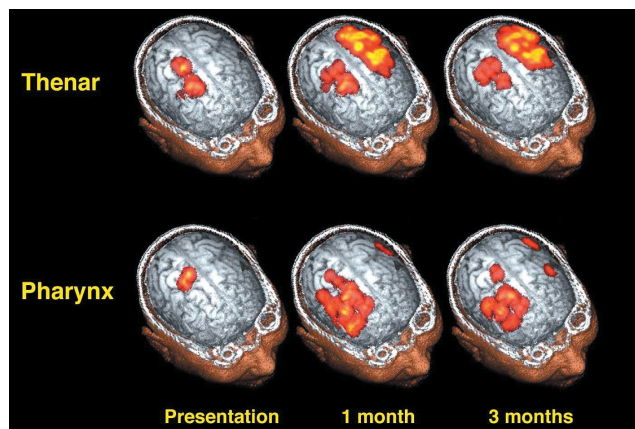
Surface rendered MRI brain images from a patient following left sided hemispheric stroke. TMS topographic data of the pharyngeal and contralateral thenar muscles have been coregistered. The patient was dysphagic at presentation but recovered and was swallowing safely at 3 months. It is evident that after stroke, the representation of the pharynx in the anterior aspect of the motor cortex and pre-motor areas expands anterolaterally in the right unaffected hemisphere at both 1 and 3 months, with little change in the affected left hemisphere. In contrast, the representation of the thenar muscles in superior motor cortex increases anteriorly and posteriorly in the affected left hemisphere over time, but remains unchanged in the unaffected right hemisphere. (Reproduced with kind permission reference 18).
